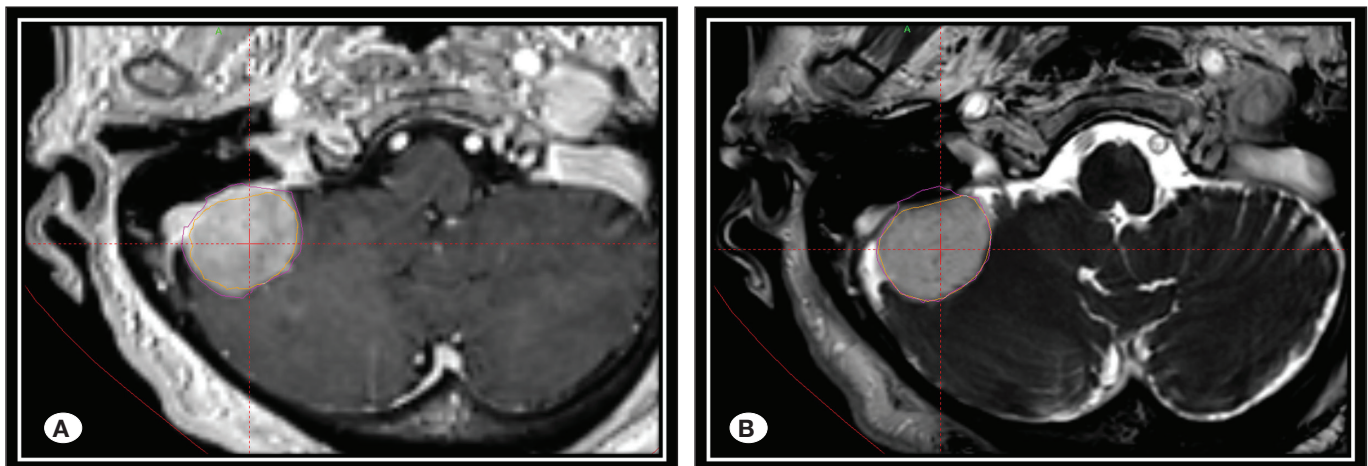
A) The purple line represents the right cerebellar meningioma border determined by T1 contrast-enhanced MRI for GKRS. B) The yellow line represents the border of the right cerebellar meningioma in the same section of the same tumor on FIESTA sequence MRI.
